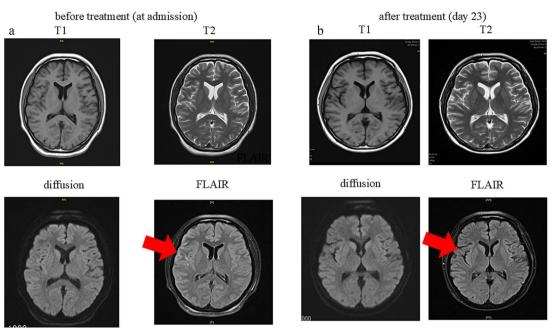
Head magnetic resonance imaging findings. (a) FLAIR image at admission. (b) FLAIR image at 23 days.
